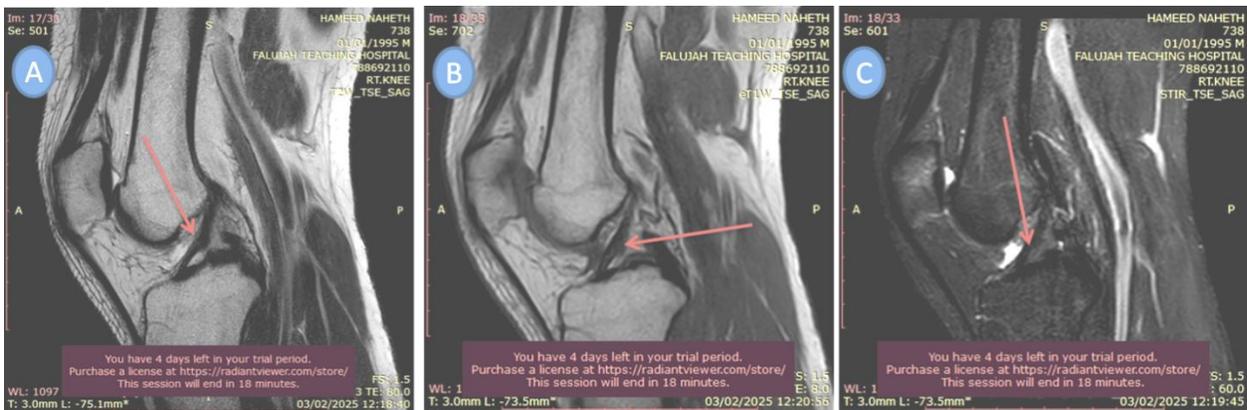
In each of A: T2, B: T1, C: STIR showing ACL tearing (arrow) of MRI Knee joint.
